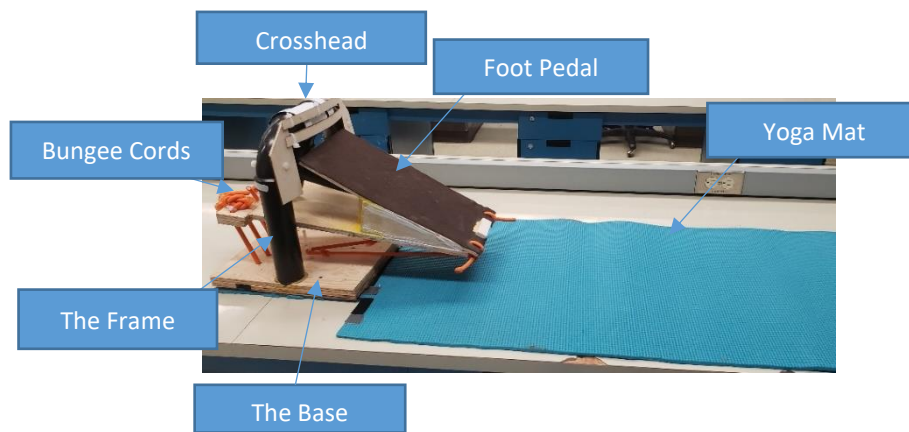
Figure A-2-1: Labelled MRI-safe loading Rig. When the foot is applied to the foot pedal, cross-head rotates around the frame, allowing the attached bungee cords, held down to the base, to be stretched hence causing resistance and force to be generated at the participant's knee.
